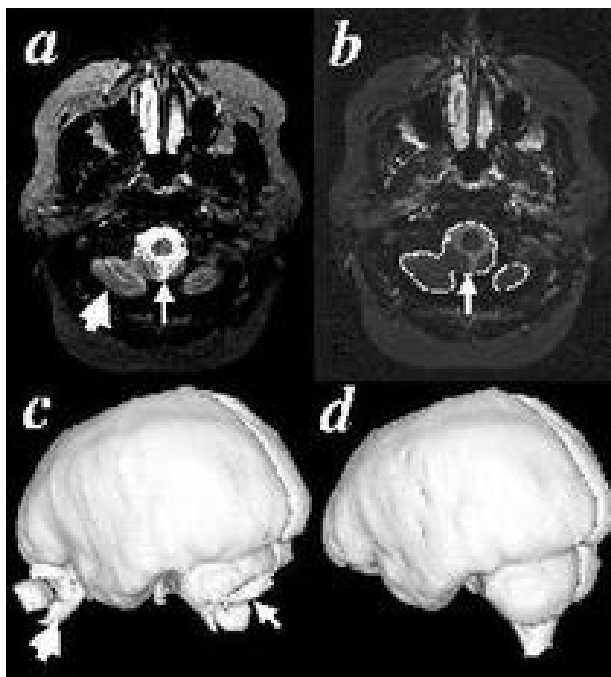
Figure a and b are from the same MRI image across the cerebellar hemispheres. (a) original T2WI overlaid with ICC from the old method (small arrow), the signal intensity is not well distributed due to intensity inhomogeneities. The cerebellar hemispheres with weak signal intensity are excluded from ICC (big arrow), (c) In the corresponding 3D rendering of the ICC, part of the posterior fossa is lost (small arrow). (b) EM segmentation inhomogeneity corrected image overlaid with the ICC from the new method (small arrow) the signal intensity is well distributed, the cerebellar hemispheres are correctly included into the ICC. (d) In the corresponding 3D rendering of the ICC, the posterior fossa appears intact.
